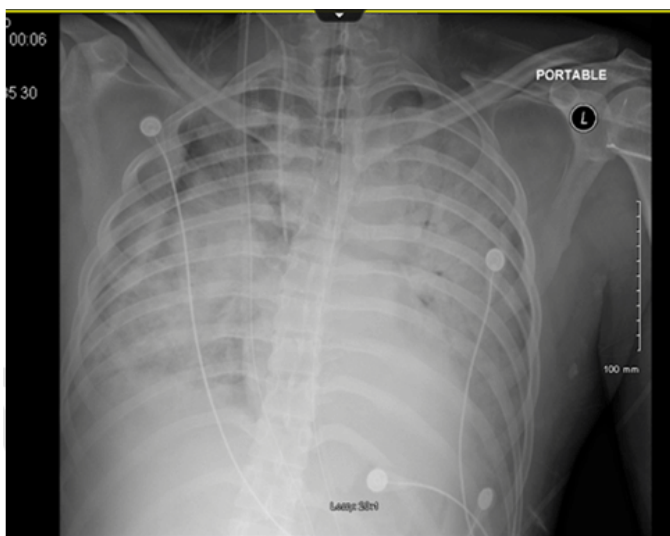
Chest X-ray in severe acute respiratory distress syndrome, before treatment with methylprednisolone.
